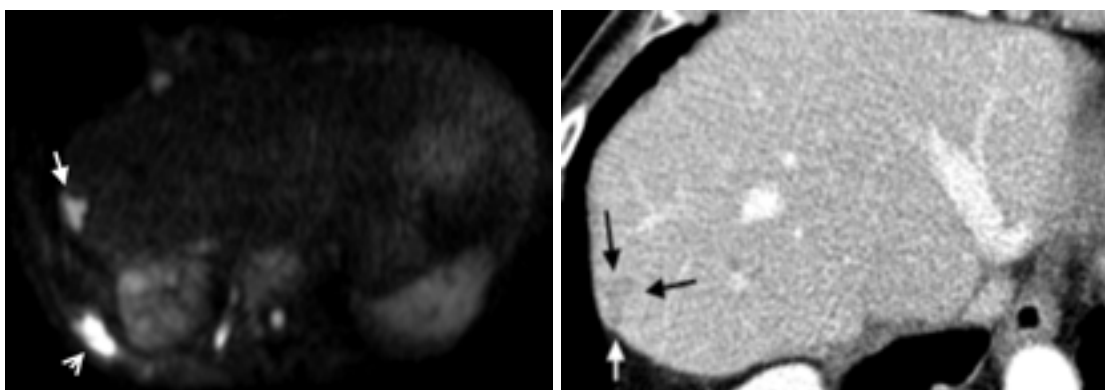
A 68-year-old woman with recurrent serous ovarian cystadenocarcinoma (Stage IIIC). No liver lesions were depicted in a scheduled control whole-body CECT. After suspected liver metastasis was detected in transverse plane DW-MRI (5608, 52, $b = 800 \text{ sec/mm}^2$) (a) (arrow) the correlating flat lesion was found in the CECT retrospectively (b). Also seen on DW-MRI (a) the recurrence of the diaphragmatic metastasis (arrowhead). The patient underwent a liver-resection and diaphragmatic resection.
